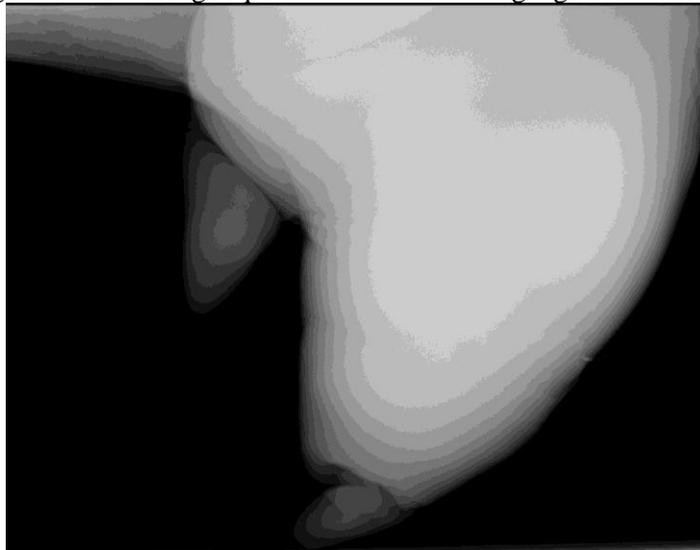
Radiographic image of the fibrosed udder.
